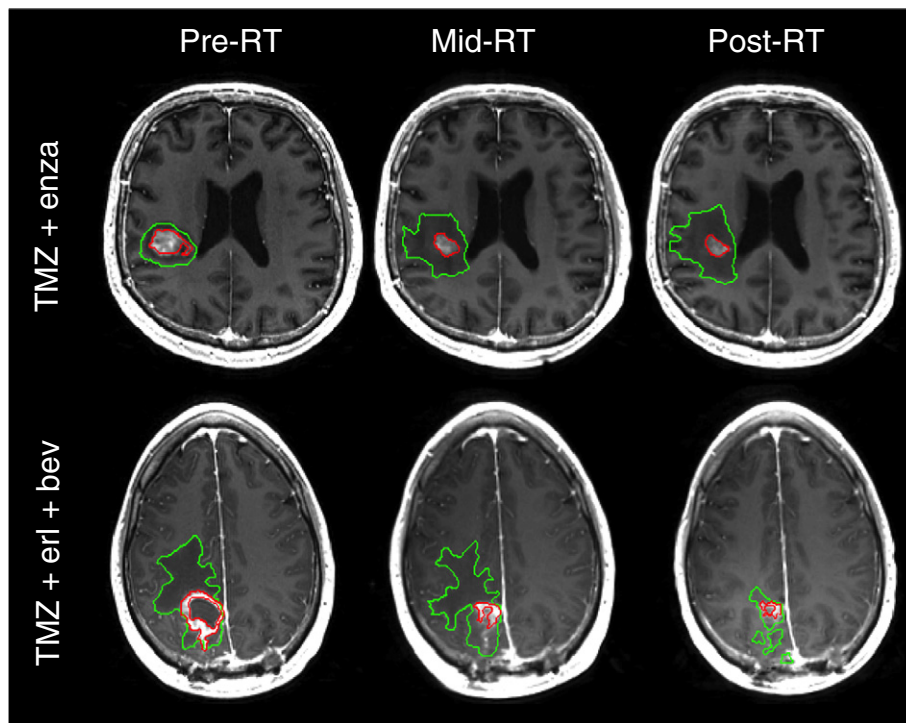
CEL (red) and T2L (green) regions of interest superimposed upon aligned T1-weighted postcontrast images from baseline, mid-RT, and post-RT scans.
